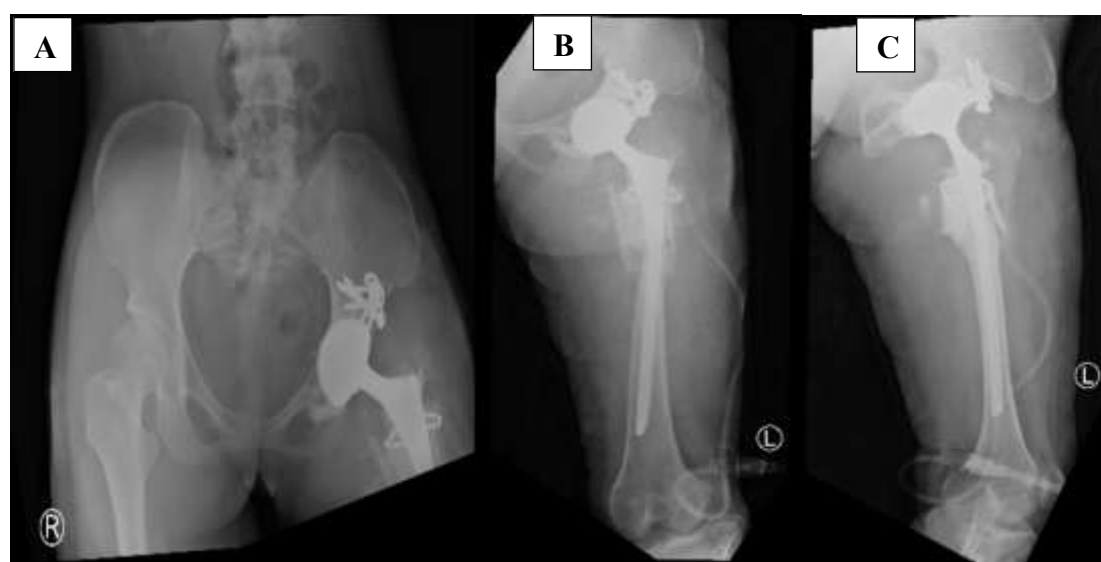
Pelvic X-Ray AP (A and B) Lateral (C) and View after revision
